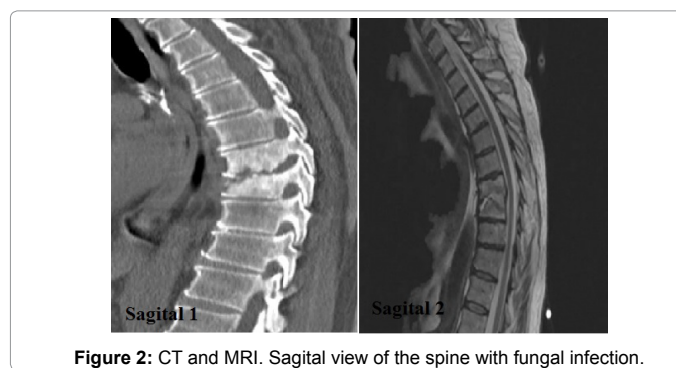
CT and MRI. Sagittal view of the spine with fungal infection.
